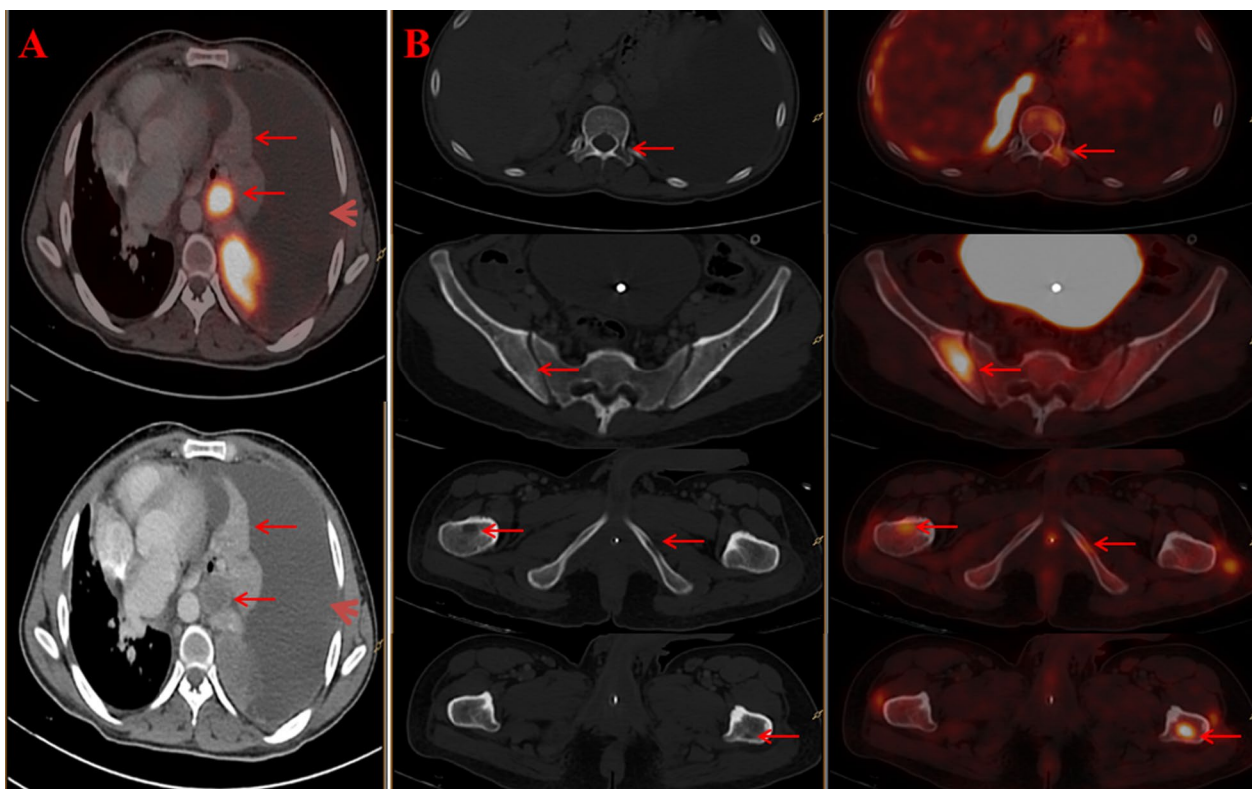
PET/CT and corresponding CT images A showing metabolically active left hilar lymph node, left pleural effusion (arrow head) and left atelectatic lung. CT and corresponding PET/CT B showing FDG avid multiple lytic skeletal lesions (left transverse process of D12 vertebra, right iliac bone, right femoral neck region, left ischiopubic ramus and left femoral neck region, respectively)
